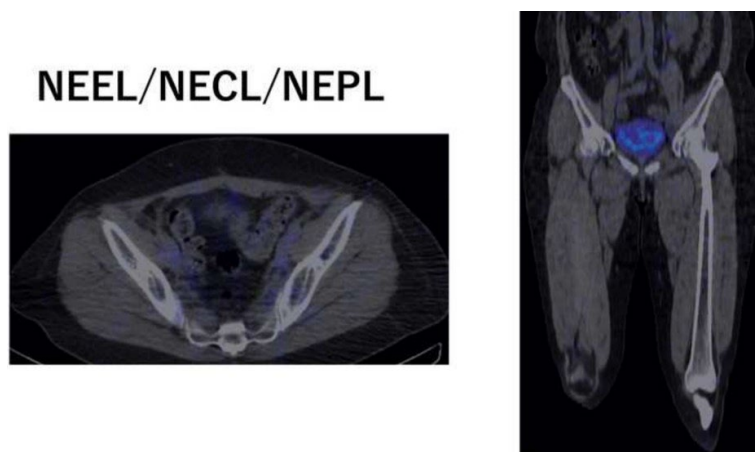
SPECT-CT images showing non-enhancement of external iliac lymph nodes (NEEL), non-enhancement of common iliac lymph nodes (NECL), and non-enhancement of periaortic lymph nodes (NEPL). The external iliac, common iliac, and para-aortic lymph nodes showed no enhancement on both sides.
